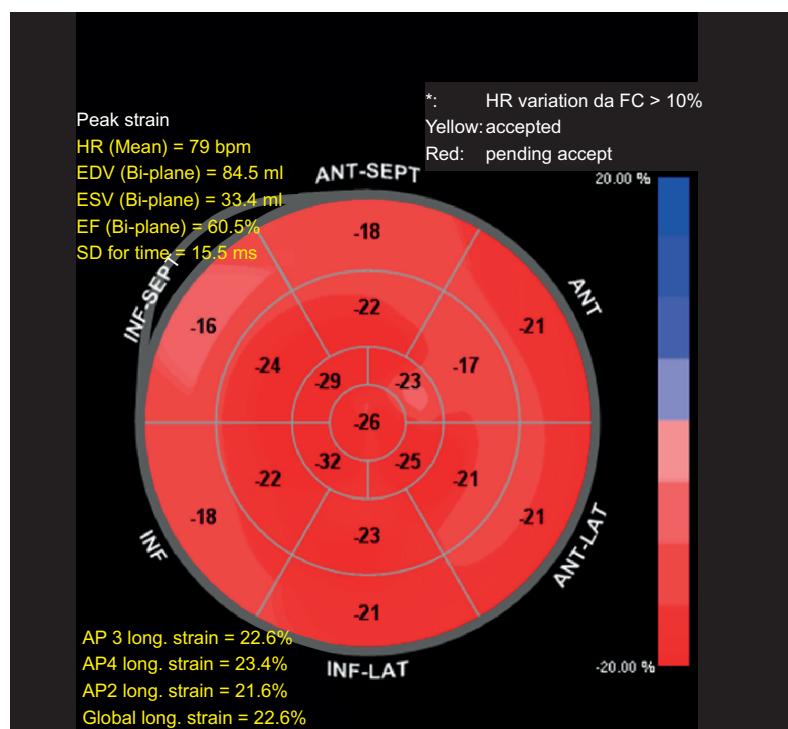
Global longitudinal strain of the second echocardiogram with normal value.
